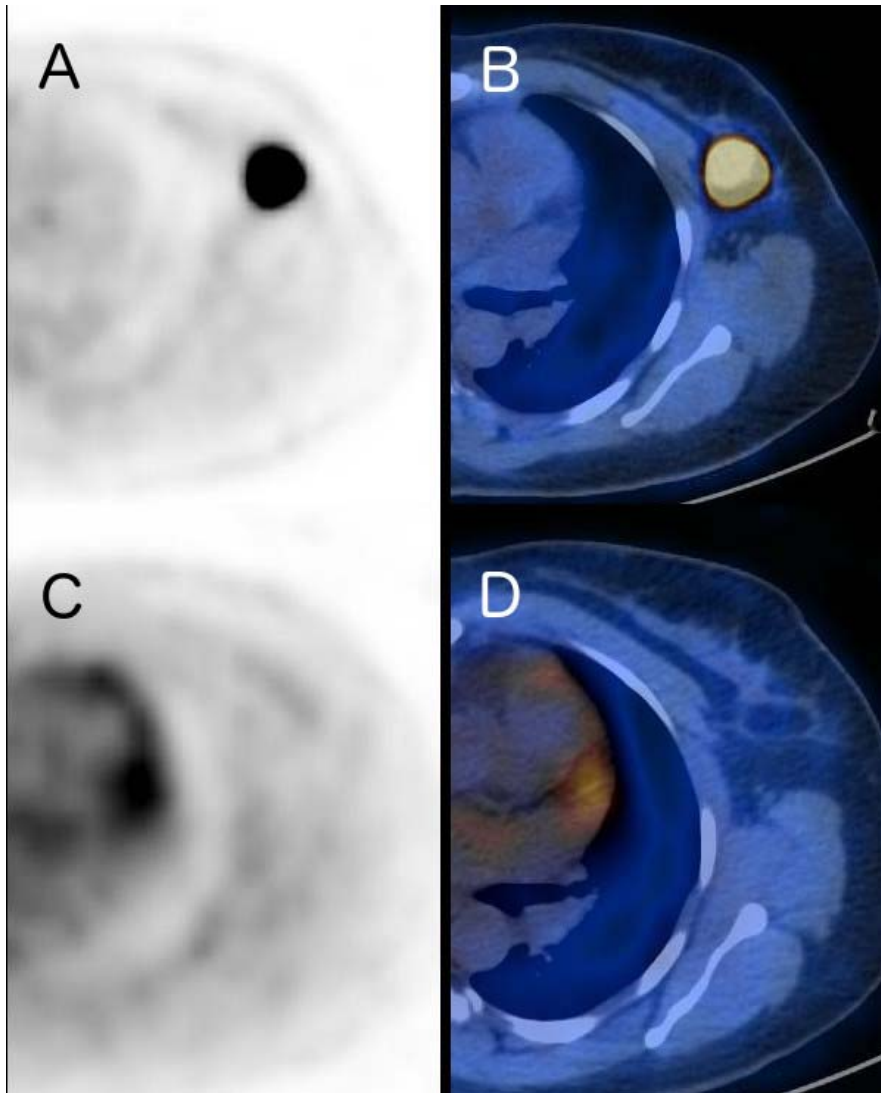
A 44-y-old patient with TNBC of the left breast. (A and B) Transaxial PET and PET/CT fused images of primary tumor at baseline; $SUV_{max} = 27.3$. (C and D) Corresponding images after two cycles of SIM; tumor SUV_{max} is 1.4 ($\Delta SUV_{max} = -95\%$). At surgery (after 4 additional cycles of chemotherapy), no residual tumor was detected. No recurrence was observed more than 1 year after surgery.
